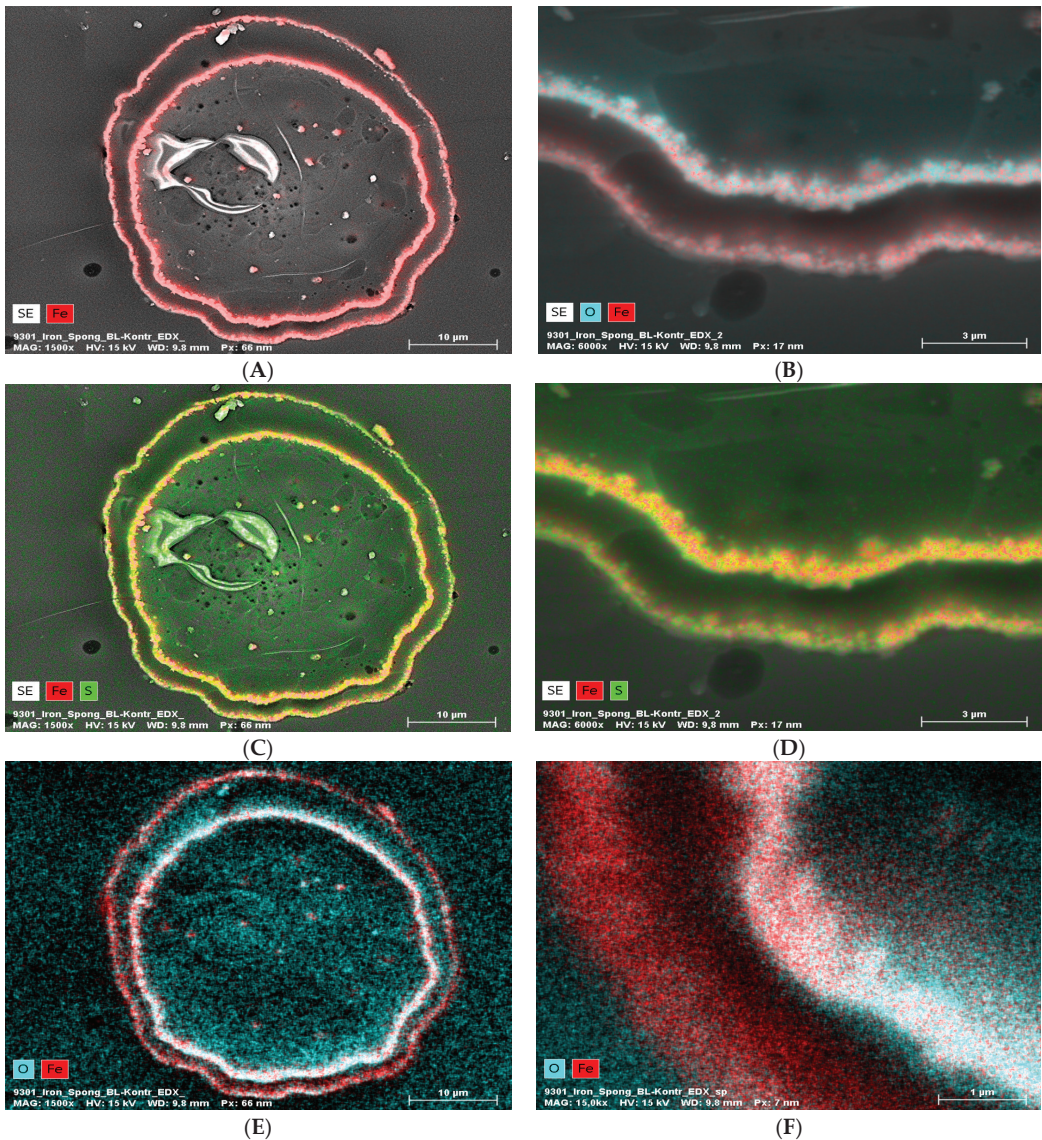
EDX analysis (elemental mapping) of a block face image cross-section of a single “Iron-Spongin after ultrasound treatment” fiber, whereby the element contents are colored in red for iron, blue for oxygen, and green for sulfur (in the case of red and green overlapping, a bright yellow color is observed). The presence of Fe and O in the two layers (A,B,E,F) is clearly visible. Sulfur seems more or less equally distributed over the cross-section (C,D). The inner layer seems to be higher in Fe and O combined with the outer layer (B,E,F).
